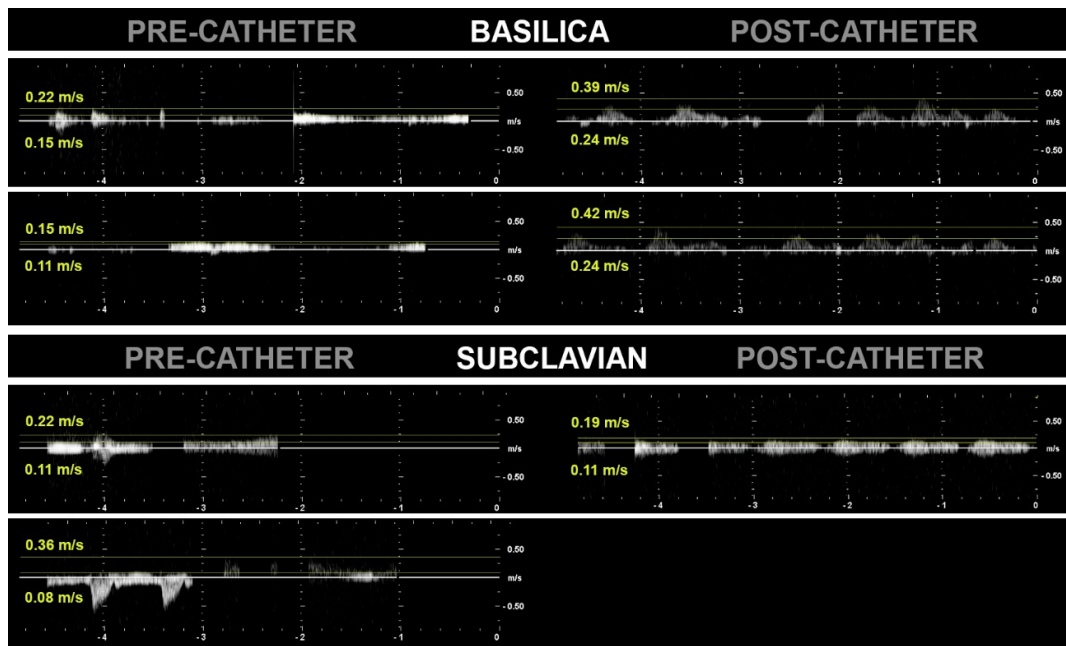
Doppler ultrasound results.
